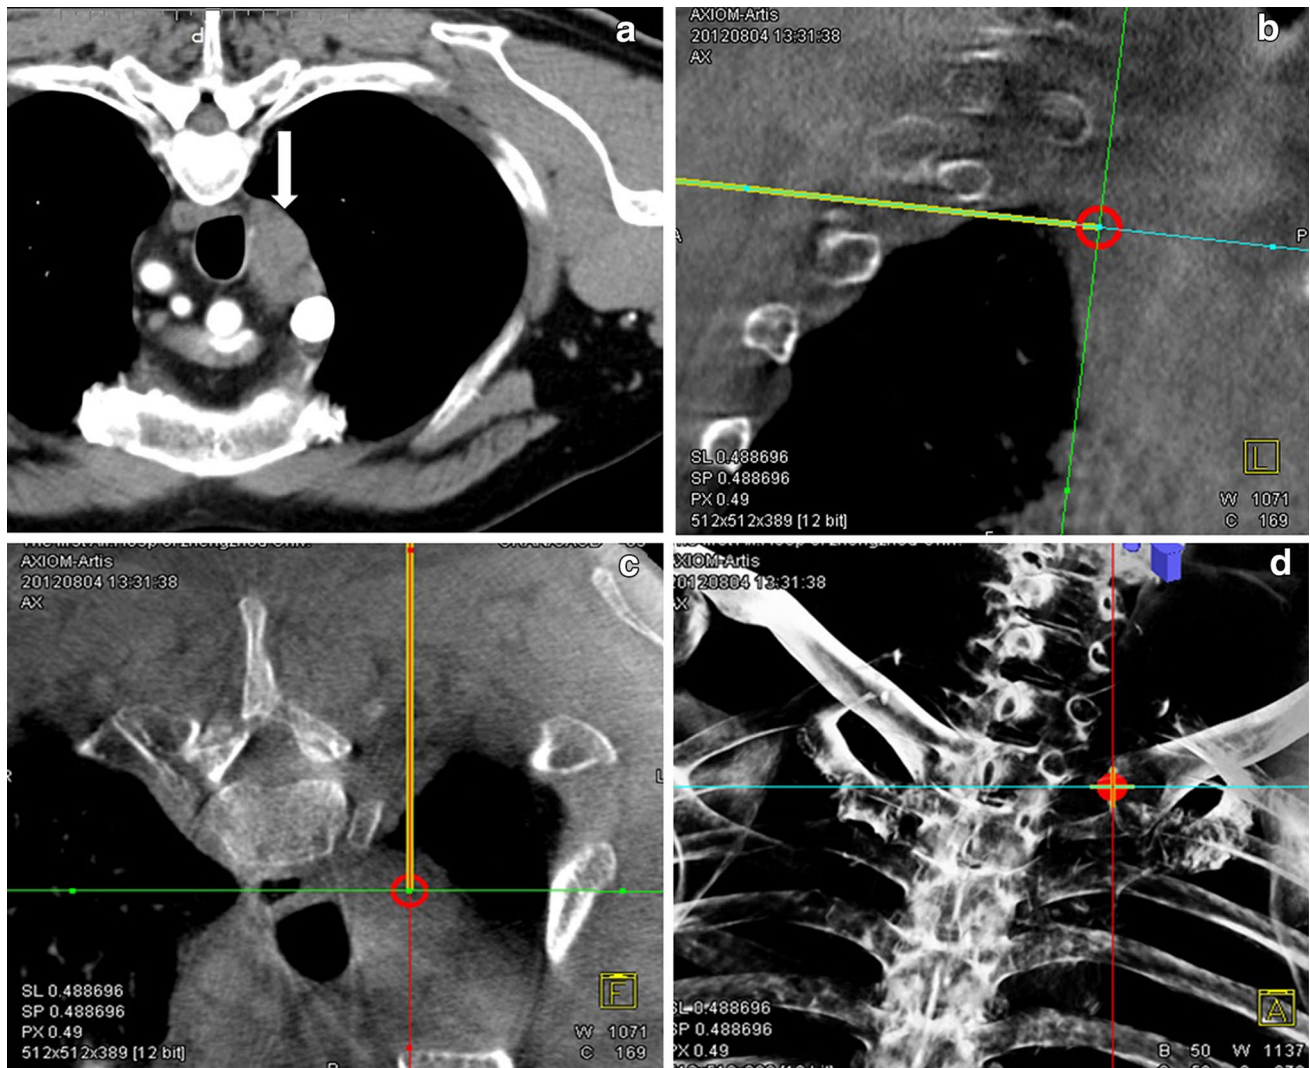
55-year-old patient, preoperative CT showed a 2.50 cm middle mediastinal lesion (*white arrow*) (a). CBCT orthogonal multiplanar images with graphics showing planned needle path (*yellow line*) into target lesion (*red circle*) (b, c). The *cross* indicated the skin entry
